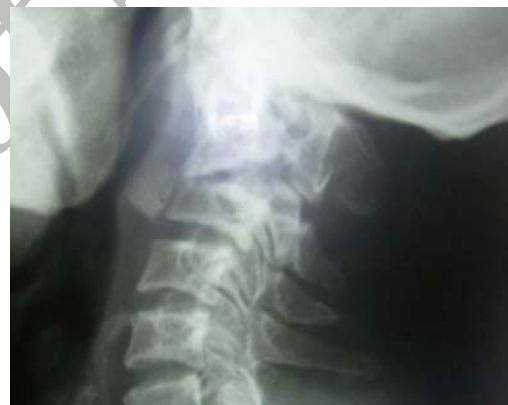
Plain X-ray of the cervical spine in the immediate postoperative period showing extrusion of the graft
